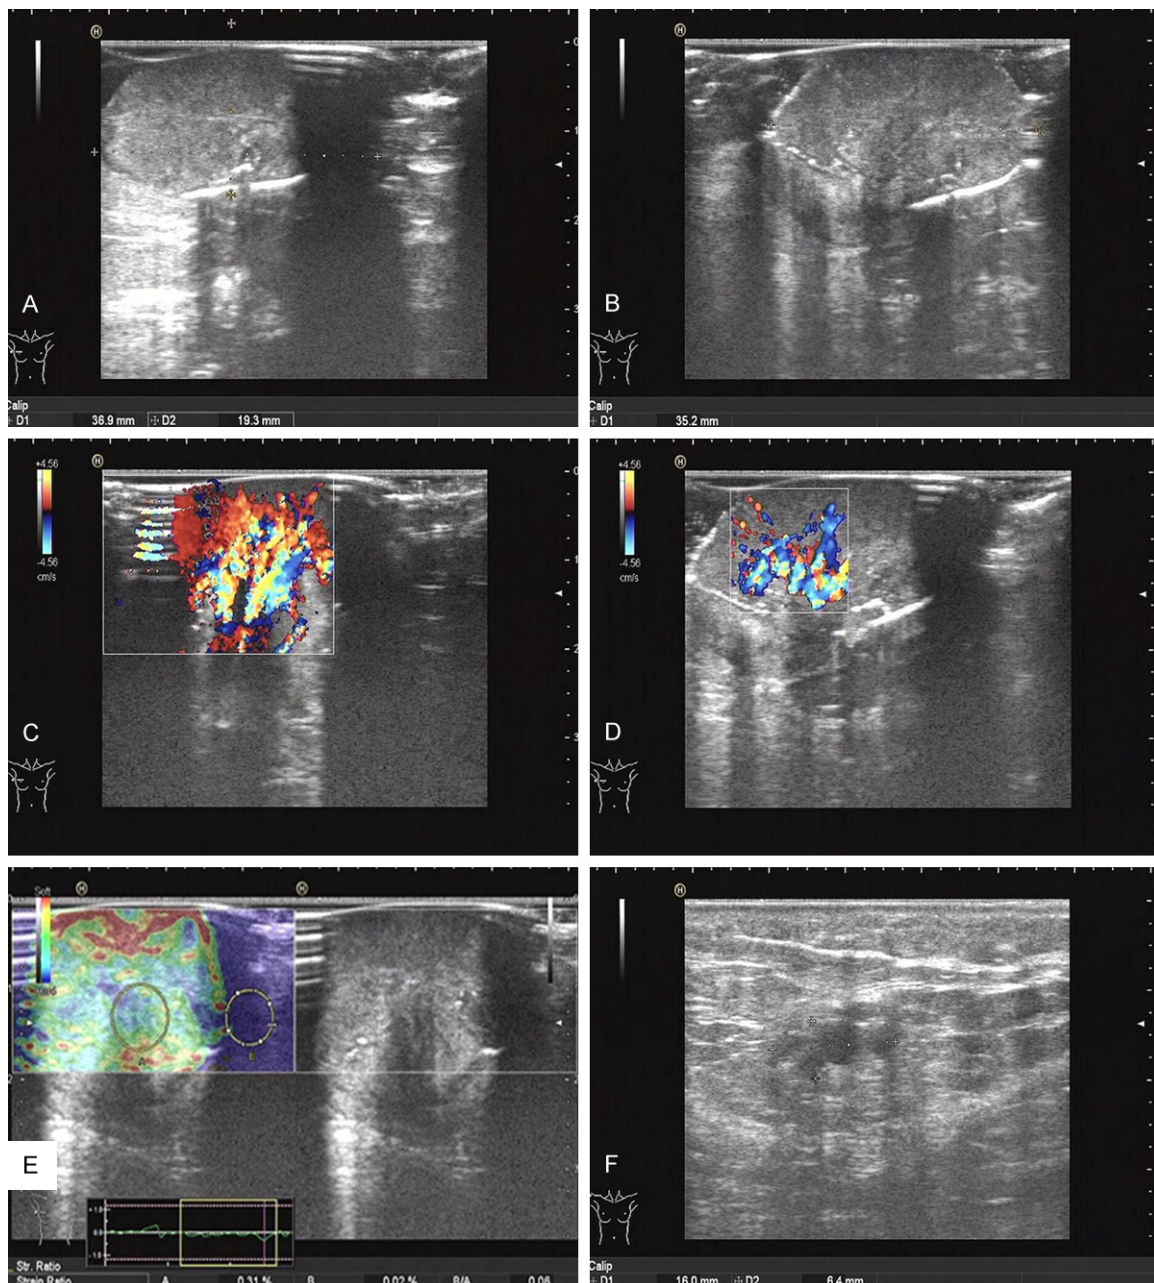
Ultrasound images of the lesion characteristics of the tumor on the right nipple and the lymphonodus on the right axillary fossa.
